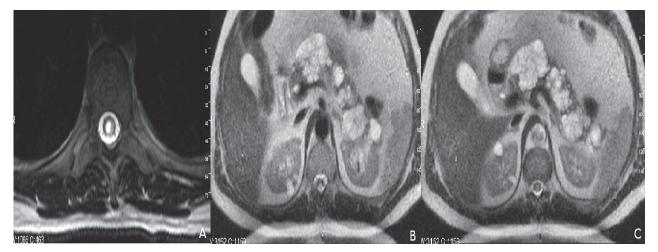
(A) Syringohydromyelic changes of spinal cord in dorsal region T2 weighted axial images. (B) MRI images with HASTE sequence showing bilateral multipl renal cysts. (C) MRI images with HASTE sequence showing pancreatic cysts.
